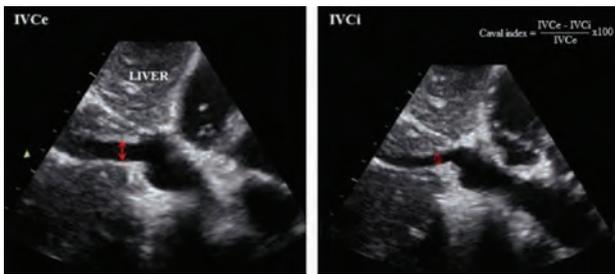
Echocardiographic measurement of inspiratory inferior vena cava (IVCI) and expiratory inferior vena cava (IVCe) diameters, and calculation of caval index.
